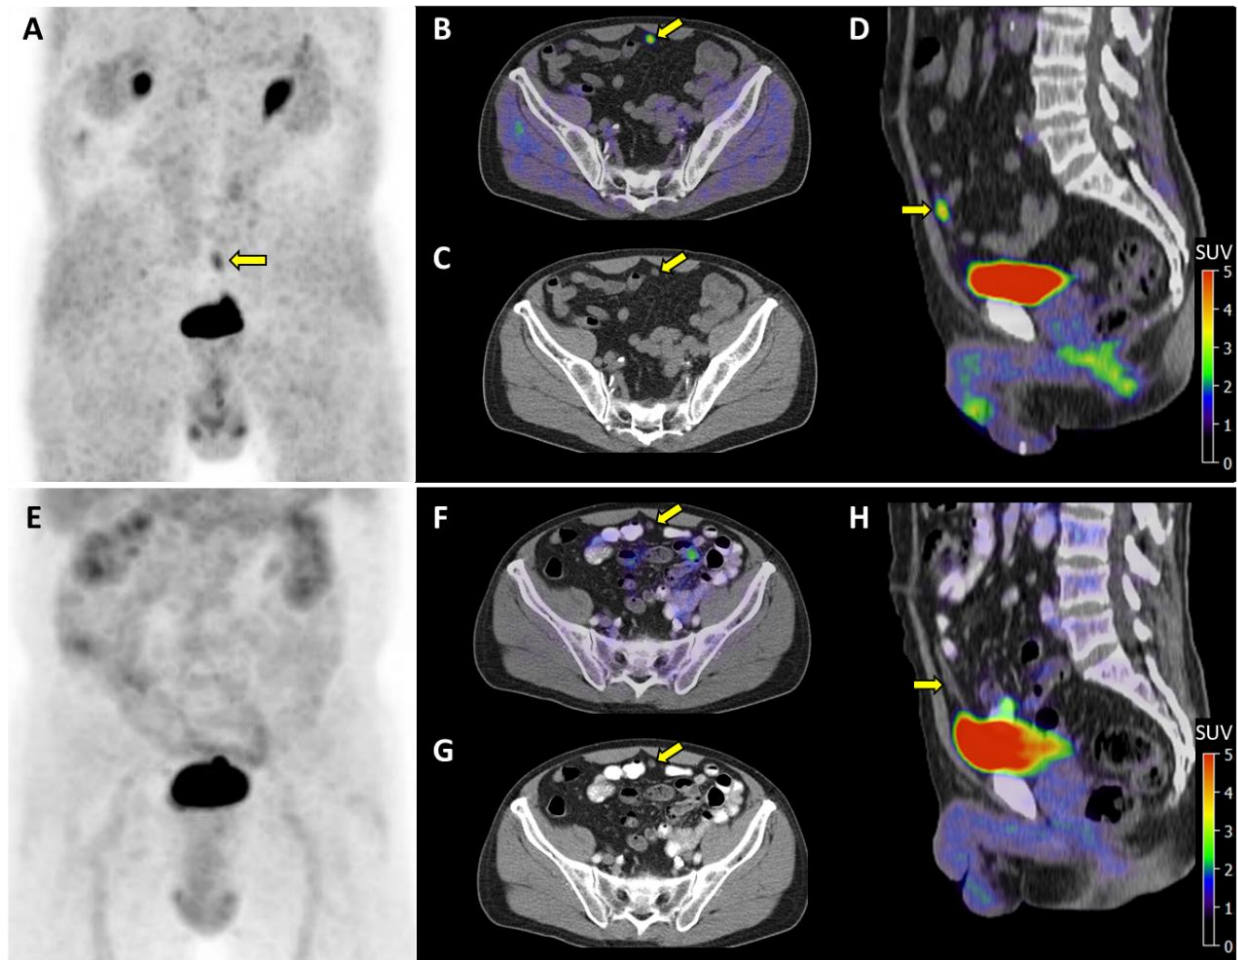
Maximum intensity projection, axial (fused, CT), and sagittal of ^{68}Ga -FAPI-46 PET/CT (top, A-D) and ^{18}F -FDG-PET/CT (bottom, E-H) images demonstrating mild FAPI uptake (SUVmax 4.1) and absent FDG uptake in a cystic structure of a urachal remnant (arrows).
